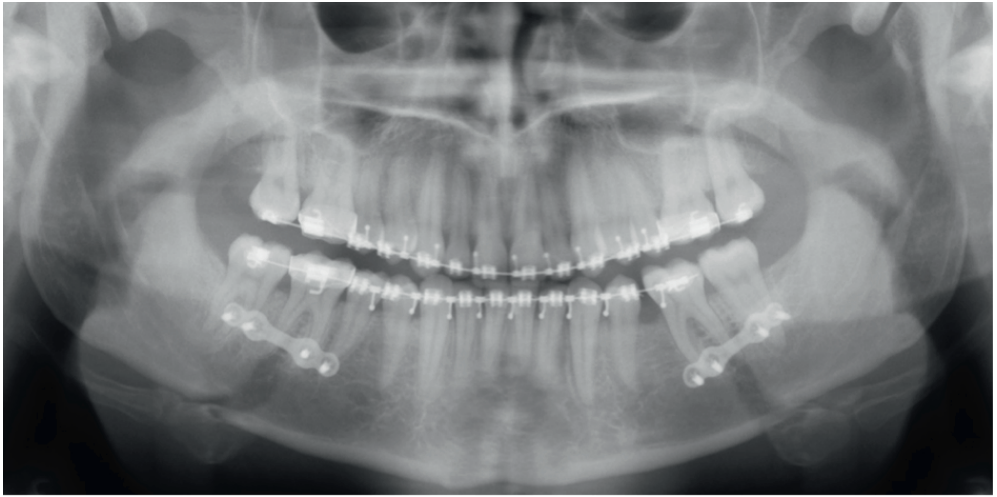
Orthopantomogram with single fixation plates inserted on each side.
